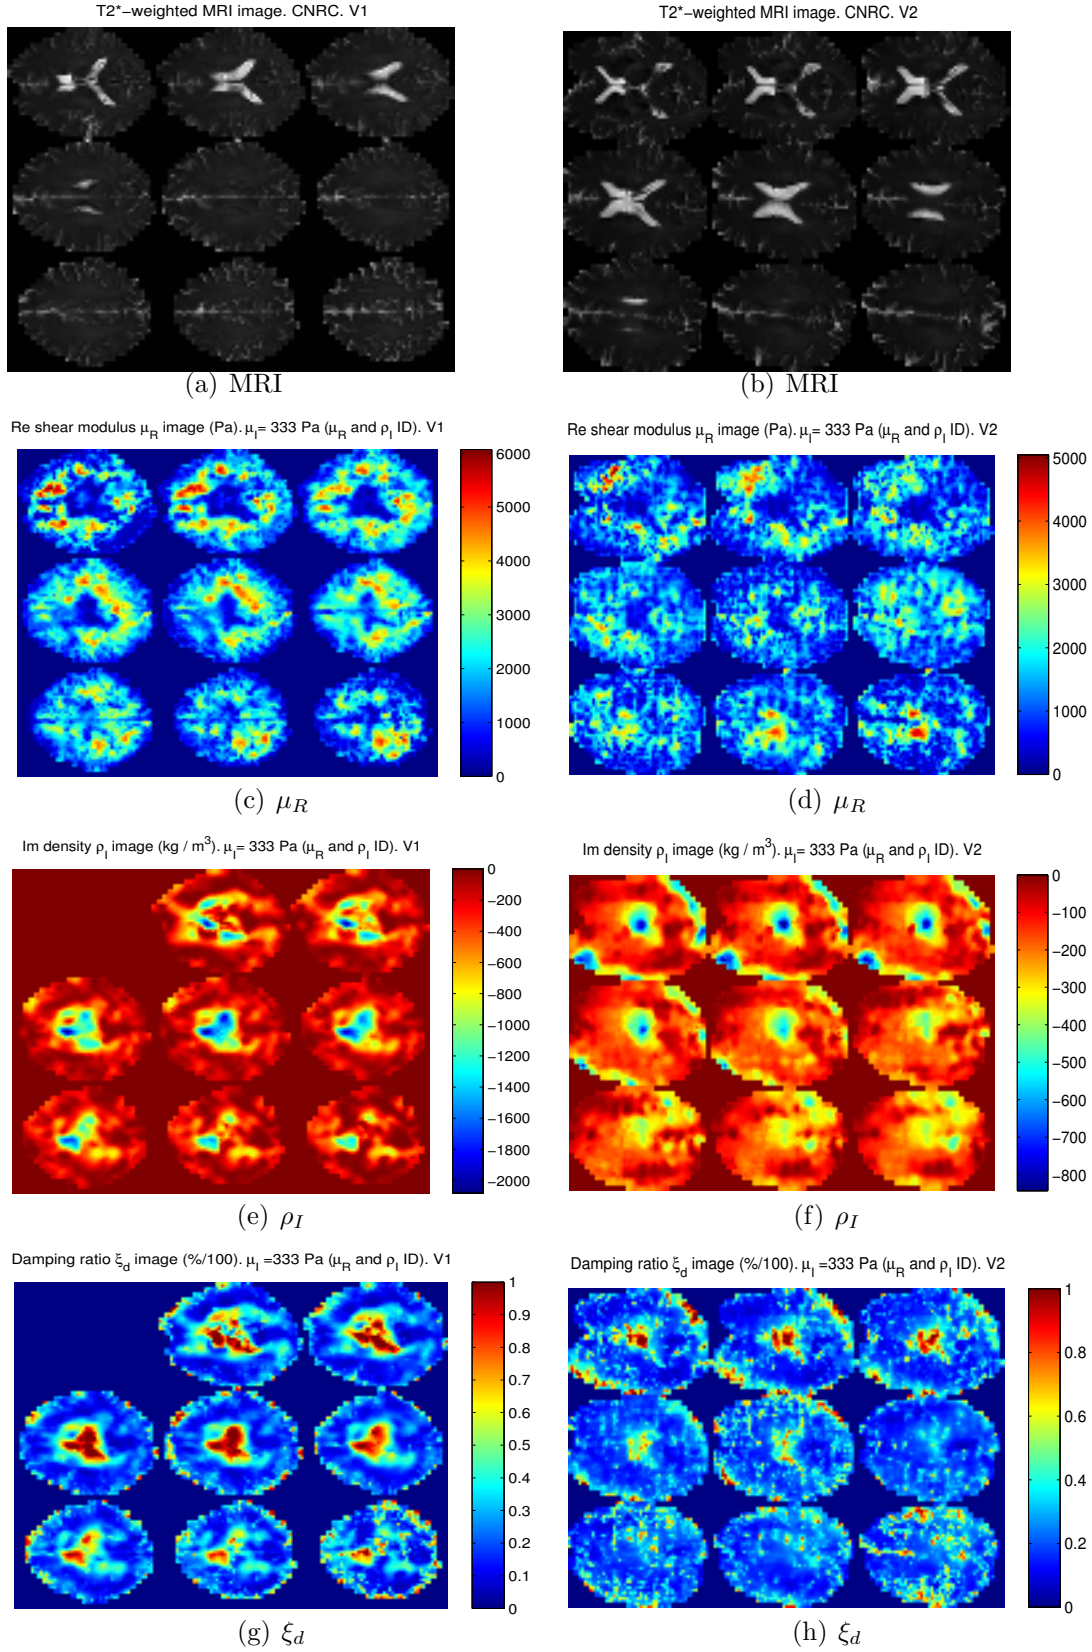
Image results of the parametric-based RD reconstruction with globally defined $\mu_I = 333$ Pa of the *in-vivo* healthy brains (subject V1 and subject V2) from Fig. 10.5 at 50 Hz (CNRC data set): (a) and (b) T2*-weighted MRI images, (c) and (d) storage modulus μ_R image (Pa); (e) and (f) imaginary density ρ_I image (kg/m^3); and (g) and (h) damping ratio ξ_d image (% / 100)
